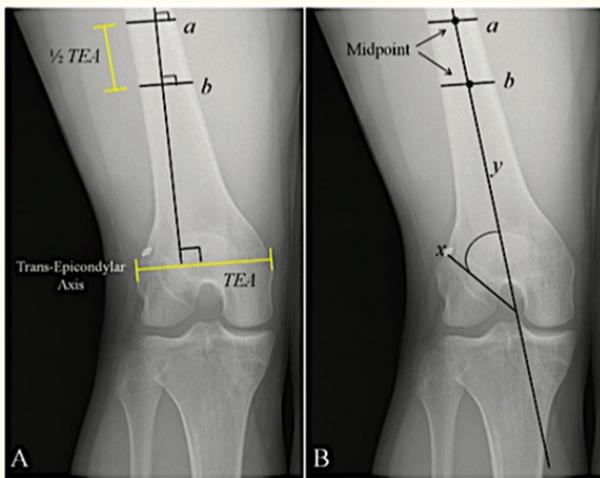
Method for determining the angle of the femoral tunnel on anterior to posterior radiography. (A) Two proximal (line a and line b) of the femoral shaft are measured parallel to the transepicondylar axis (ASD), as described above. (B) The midpoints of line a and line b are determined to draw an estimate of the longitudinal axis of the femur (line y). A line dividing from the femoral tunnel, line X; and line Y are used for the angle of the femoral tunnel [27].
